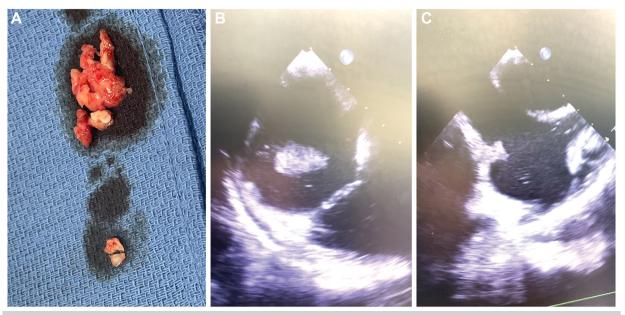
A, Extracted thrombus with a chronic, fibrinous appearance. B, Preprocedure echocardiogram showing thrombus burden. C, Postprocedure echocardiogram confirming resolution.
